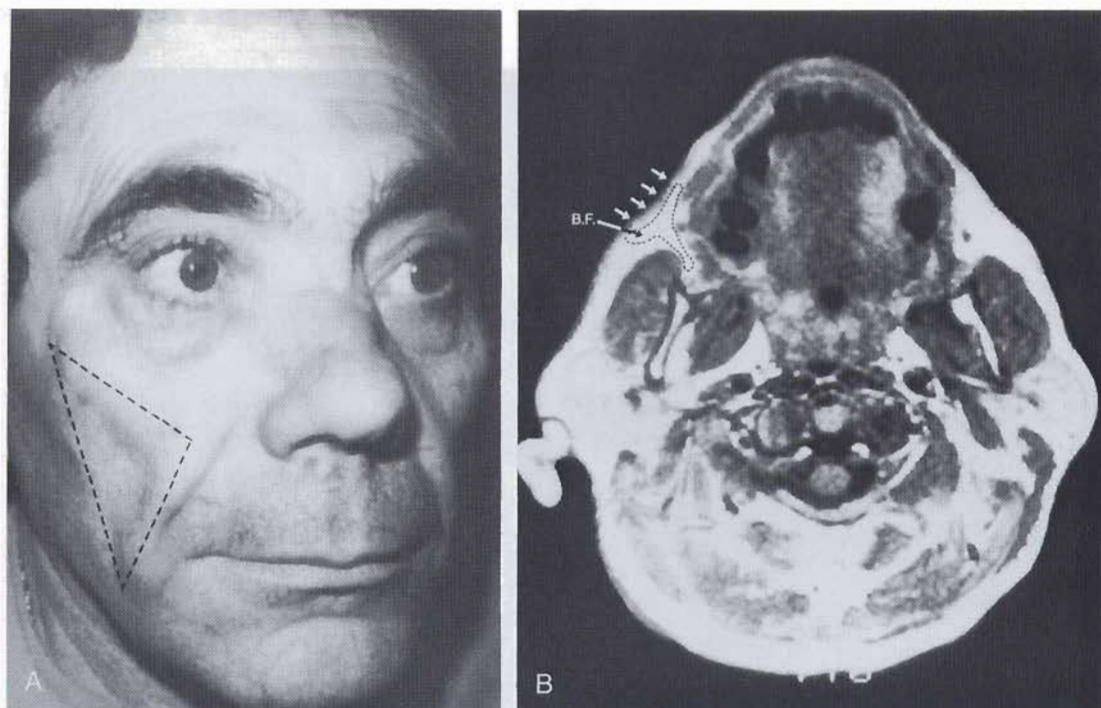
A, Case 3. A 61-year-old man with a midfacial depression localized to the right submalar triangle. B, The MR imaging findings of the midfacial depression seen in the photograph correlate to the findings found clinically. Arrows indicate the area of facial depression. BF = buccal fat pad.
